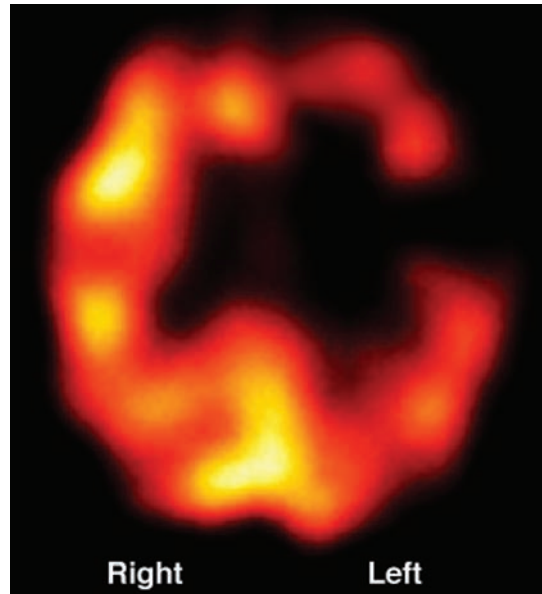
Resting xenon-133 (¹³³Xe)-SPECT image demonstrating chronic left anterior temporal hypoperfusion 1 year post severe TBI.
